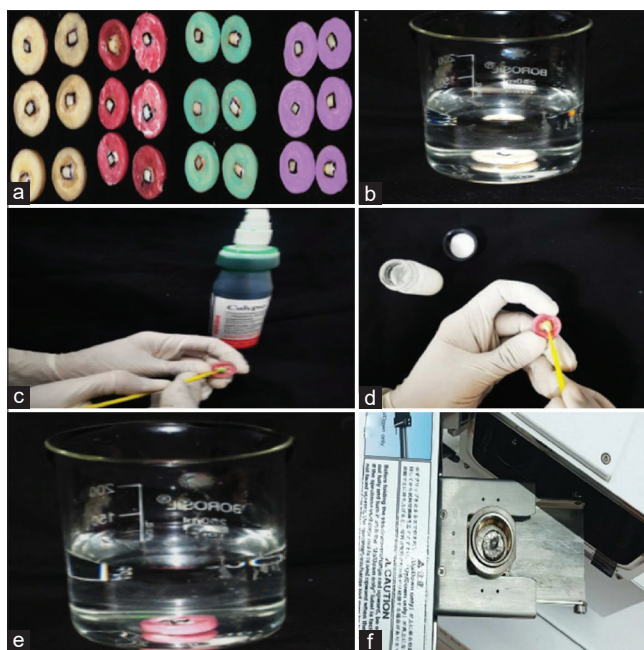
Study Setting I (a) Sample preparation, I (b) Artificial white spot lesion creation, I (c) Chlorhexidine pretreatment, I (d) Application of remineralizing agents, I (e) pH cycling, I (f) Energy-dispersive X-ray analysis
